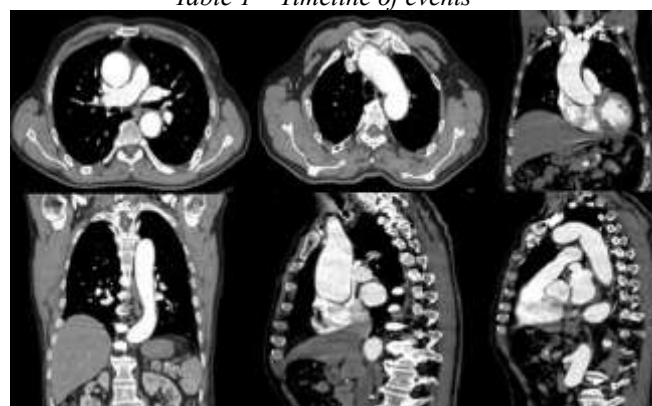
Chest CT scan with intravenous contrast material, axial, coronal and sagittal planes, revealed ascending aorta aneurysm (max 47 mm), aortic arch aneurysm (43 mm), aortic arch and descending thoracic aorta showing areas of curvature and narrowing (27-43 mm), thoraco-abdominal aortic kinking (30-41 mm).
